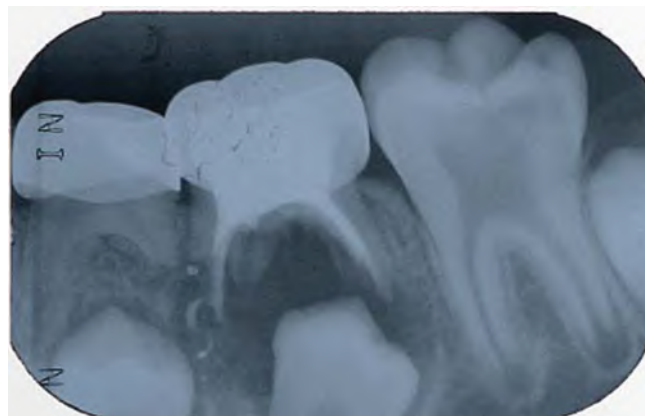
Follow-up periapical radiograph of an unsuccessful root canal in a primary mandibular left second molar. Note the interradicular and periapical radiolucency, and displacement of the permanent premolar successor. (Courtesy of Dr. Moti Moskovitz, Jerusalem, Israel.)
